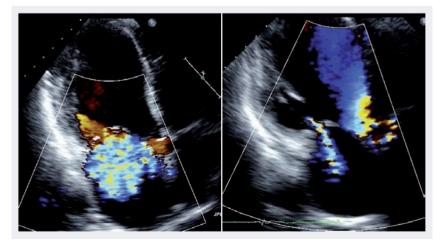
Color Doppler echocardiograms before (left panel) and 1 month after (right panel) implantation of a Carillon[®] (Cardiac Dimensions, Inc., WA, USA) device, demonstrating a marked decrease in mitral regurgitation.
